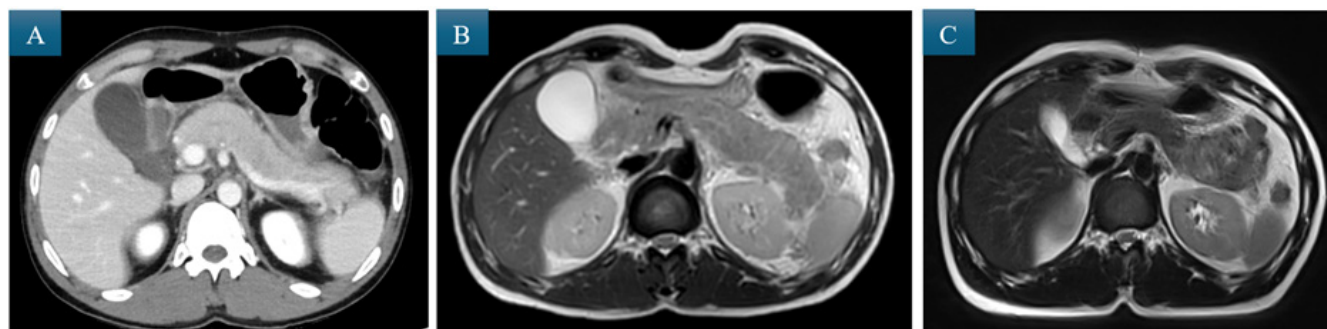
A) Contrast-enhanced CT of the abdomen and pelvis showing diffuse pancreatic enlargement with edema, peripancreatic fluid, and fat blurring, B) Abdominal MRI (T2) showed "sausage-shaped" pancreas; enlargement of pancreatic parenchyma with restricted diffusion and homogenous filling, C) Follow-up abdominal MRI (T2) showed complete resolution of the findings of the initial MRI.
